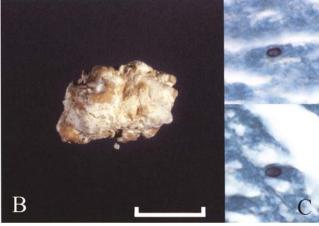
A,B. Broncholith. A. Broncholith (arrow) obstructs right lobar bronchus on computed tomography (CT) scan. B. Patient subsequently expectorated this chalky white
